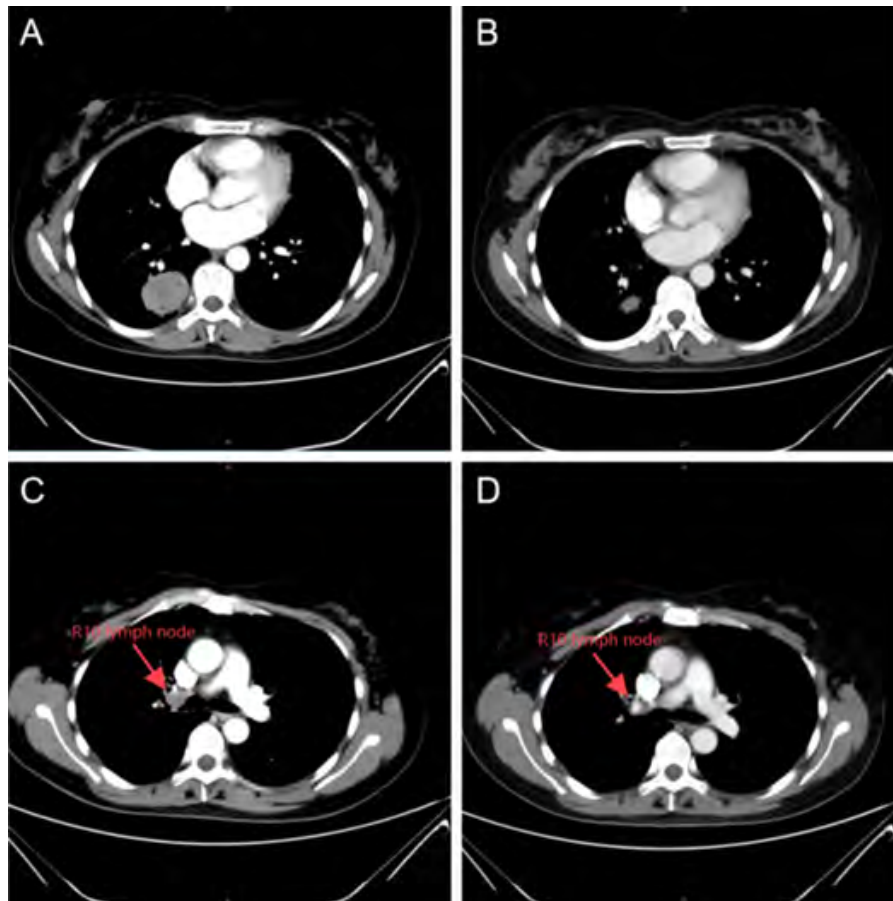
Changes in mass and hilar lymph nodes before and after lorlatinib treatment characterized by (A) Enhanced CT before lorlatinib treatment (30 November 2023) indicated a mass in the right lung's lower lobe, measuring approximately 4.2 cm × 3.7 cm × 3.3 cm; (B) Enhanced CT scan post-lorlatinib administration (10 March 2024) indicated a significantly smaller right lung's lower lobe mass, with a cross-sectional size of approximately 1.6 cm × 1.1 cm; (C) Enhanced CT before lorlatinib treatment (30 November 2023) indicated an enlarged R10 hilar lymph node, compressing the ductal opening of the right lung's upper lobe; (D) Enhanced CT post-lorlatinib (10 March 2024) revealed that the R10 hilar lymph node decreased in size when compared with the previous finding, and the luminal narrowing of the right lung's upper lobe was resolved.
